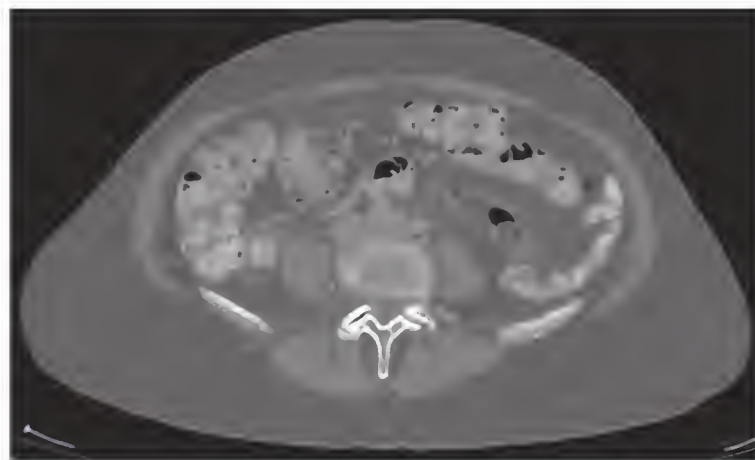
Lumbar spine stenosis. Computed tomography shows a thickened ligamentum flavum, facet joint hypertrophy, and posterior disk bulging. Note the absence of epidural fat along with a trefoil deformity of the lumbar spinal canal.
